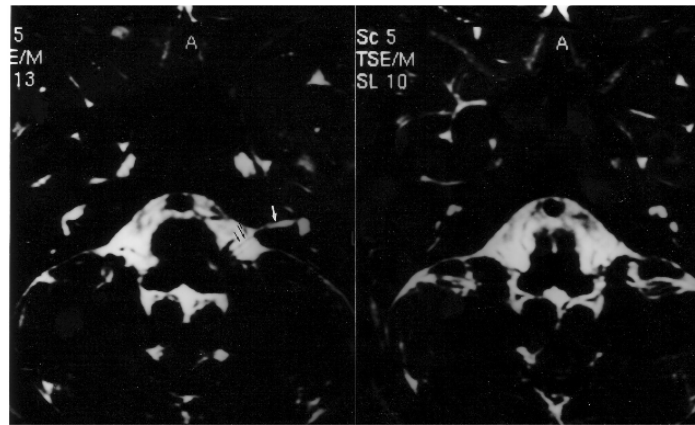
Axial 0.7mm T2 weighted MR image of IAM showing absence of nerve bundle on the right side and a hypoplastic nerve on the left side (arrow). (Patient).
